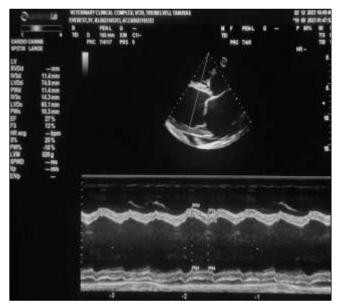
Echocardiography mesearement
